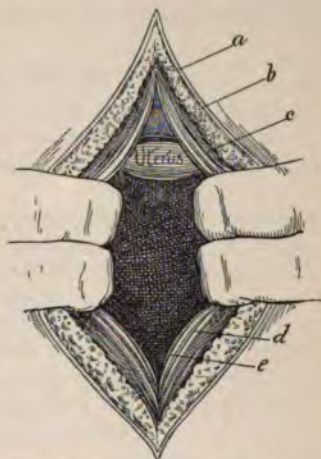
EXPLORATION OF THE PERITONEAL CAVITY BY INSPECTION (page 907).
